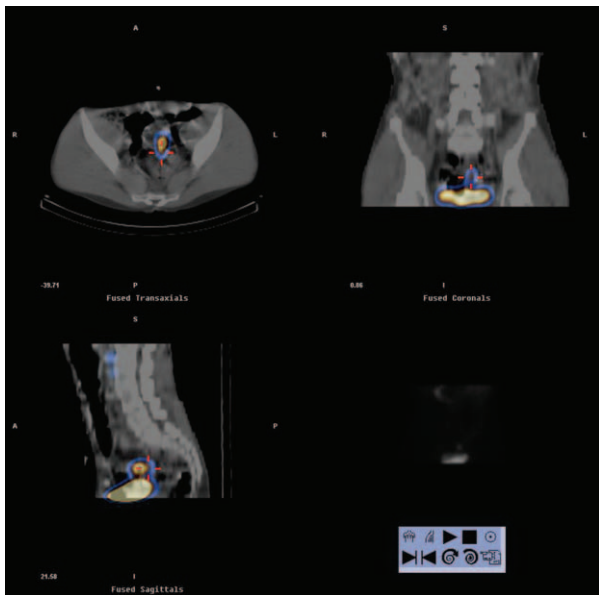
SPECT/CT showing focal radiotracer uptake projected in loops of small bowel allowing precise location of the diverticulum facilitating surgical planning.
